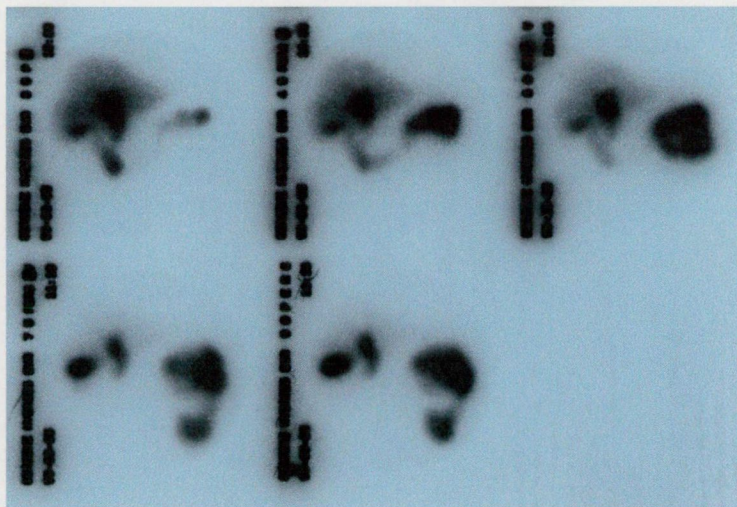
Representative hepatobiliary scintigraphy on a patient with insufficient GB filling at 60 min, which was rapidly enhanced after GTN administration.
